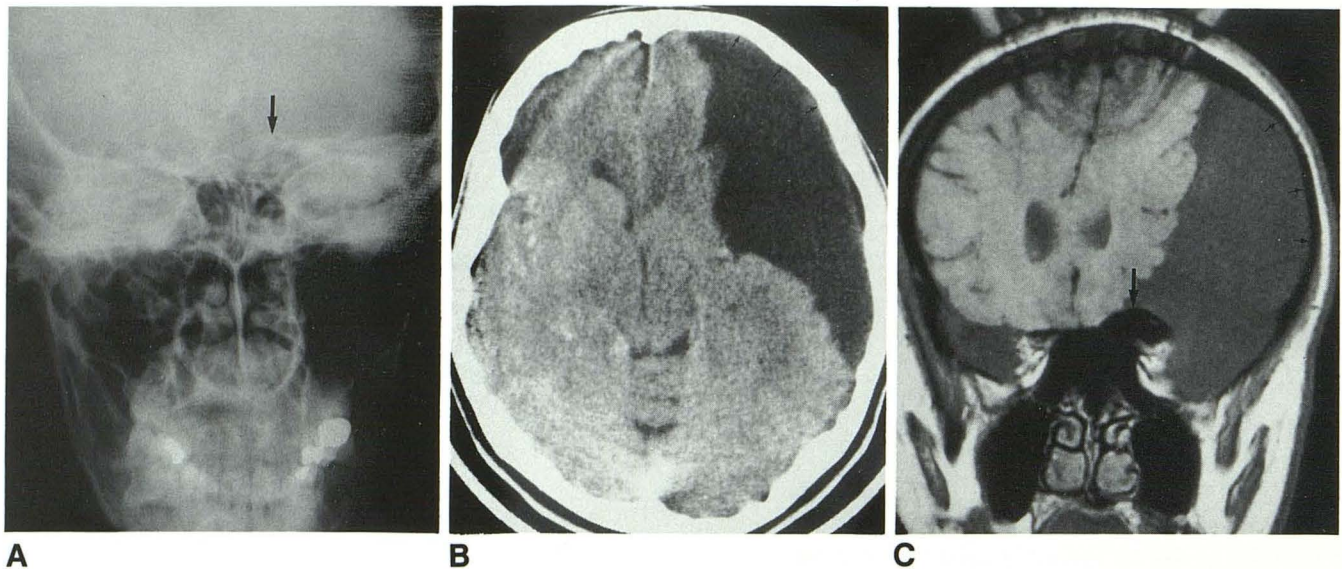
A–C, Plain skull film (A) and coronal T1-weighted MR image (C) show “ballooning” of sphenoid sinus (*large arrow*). Large arachnoid cyst is seen on CT (B) and MR (C). Remodeling of the inner table of skull (B and C) is also seen (*small arrows*).
